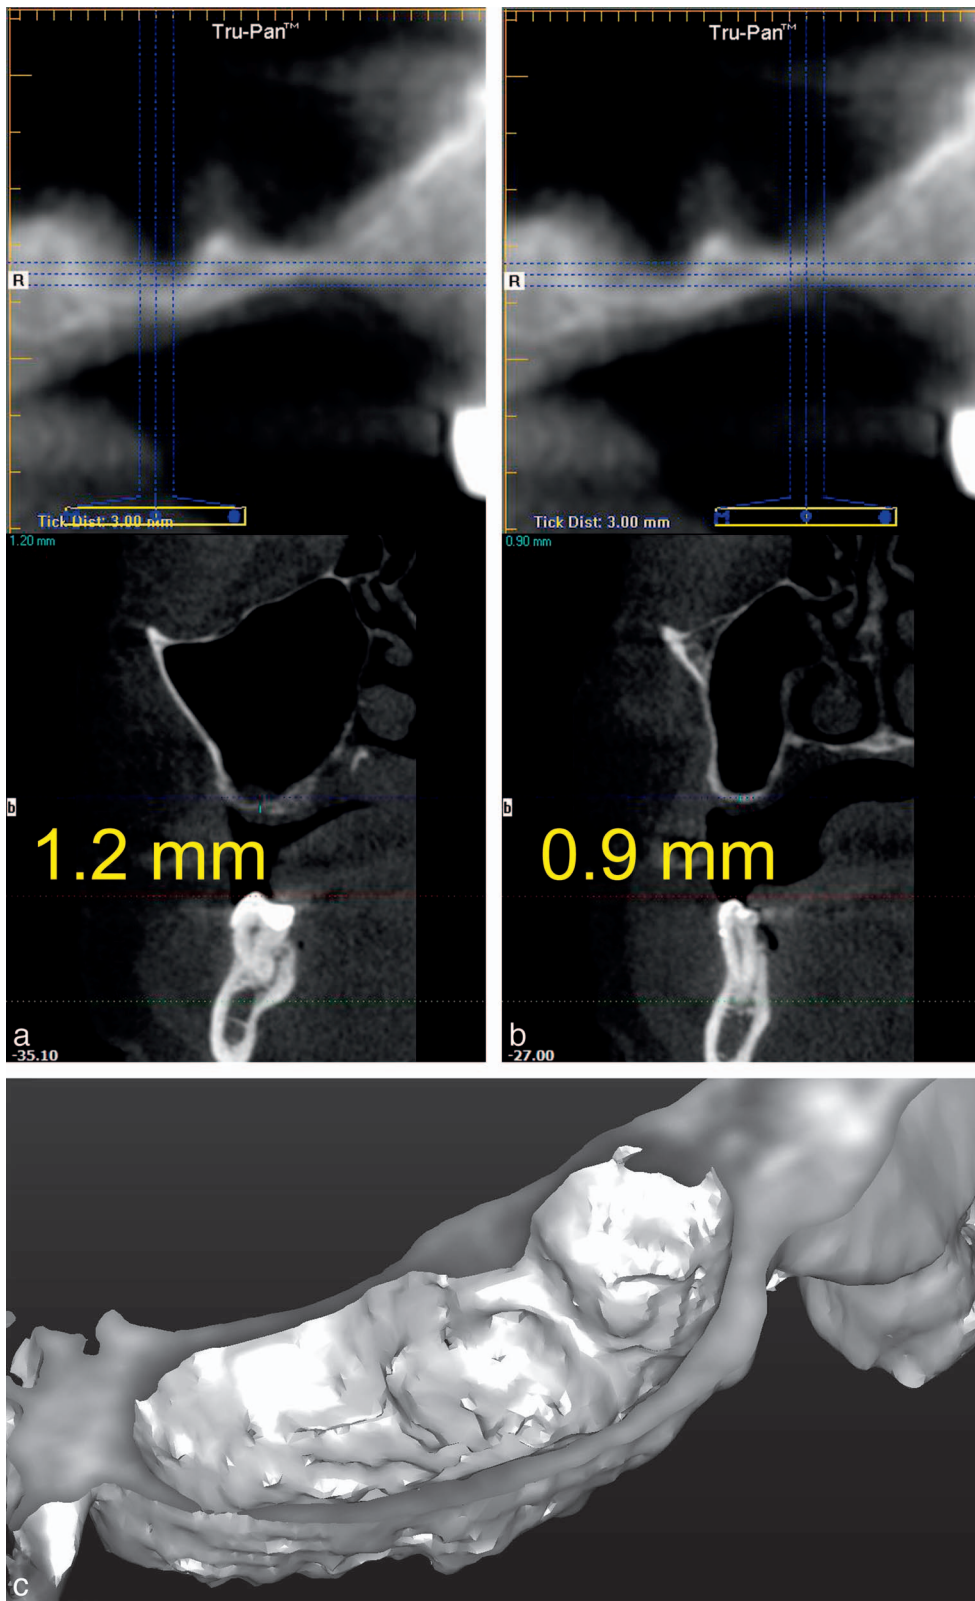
Clinical situation 1: edentulous posterior maxilla with large maxillary sinus. (a) Cone beam computerized tomography (CBCT) image; posterior crestal osteotomy site; sinus bone height = 12.2 mm. (b) CBCT image; anterior crestal osteotomy site; sinus bone height = 15.1 mm. (c) Simplant 3D image of maxillary sinus interior anatomy. Note the clearly defined, dome-shaped augmentation of bone in the sinus.
